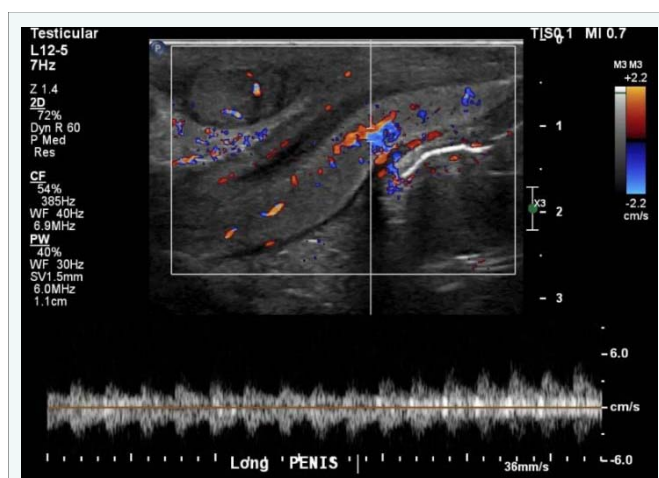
Penile duplex ultrasound (long axis) from Case 1 demonstrating normal penile (arterial) blood flow.
